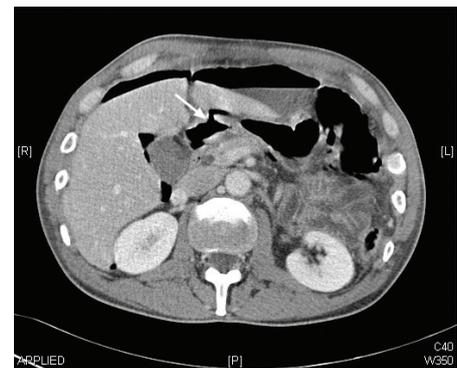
Axial CT demonstrating free intraperitoneal gas and defect in anterior wall of duodenum. (arrowed)
